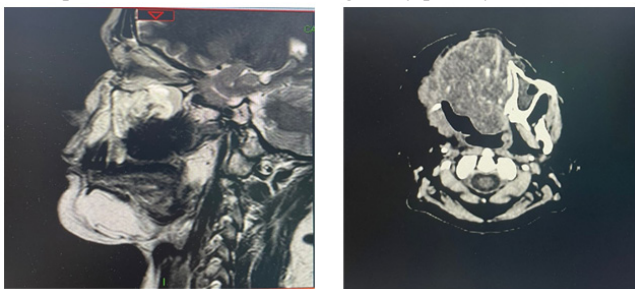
MRI of the second mandibular lesion on the right.
